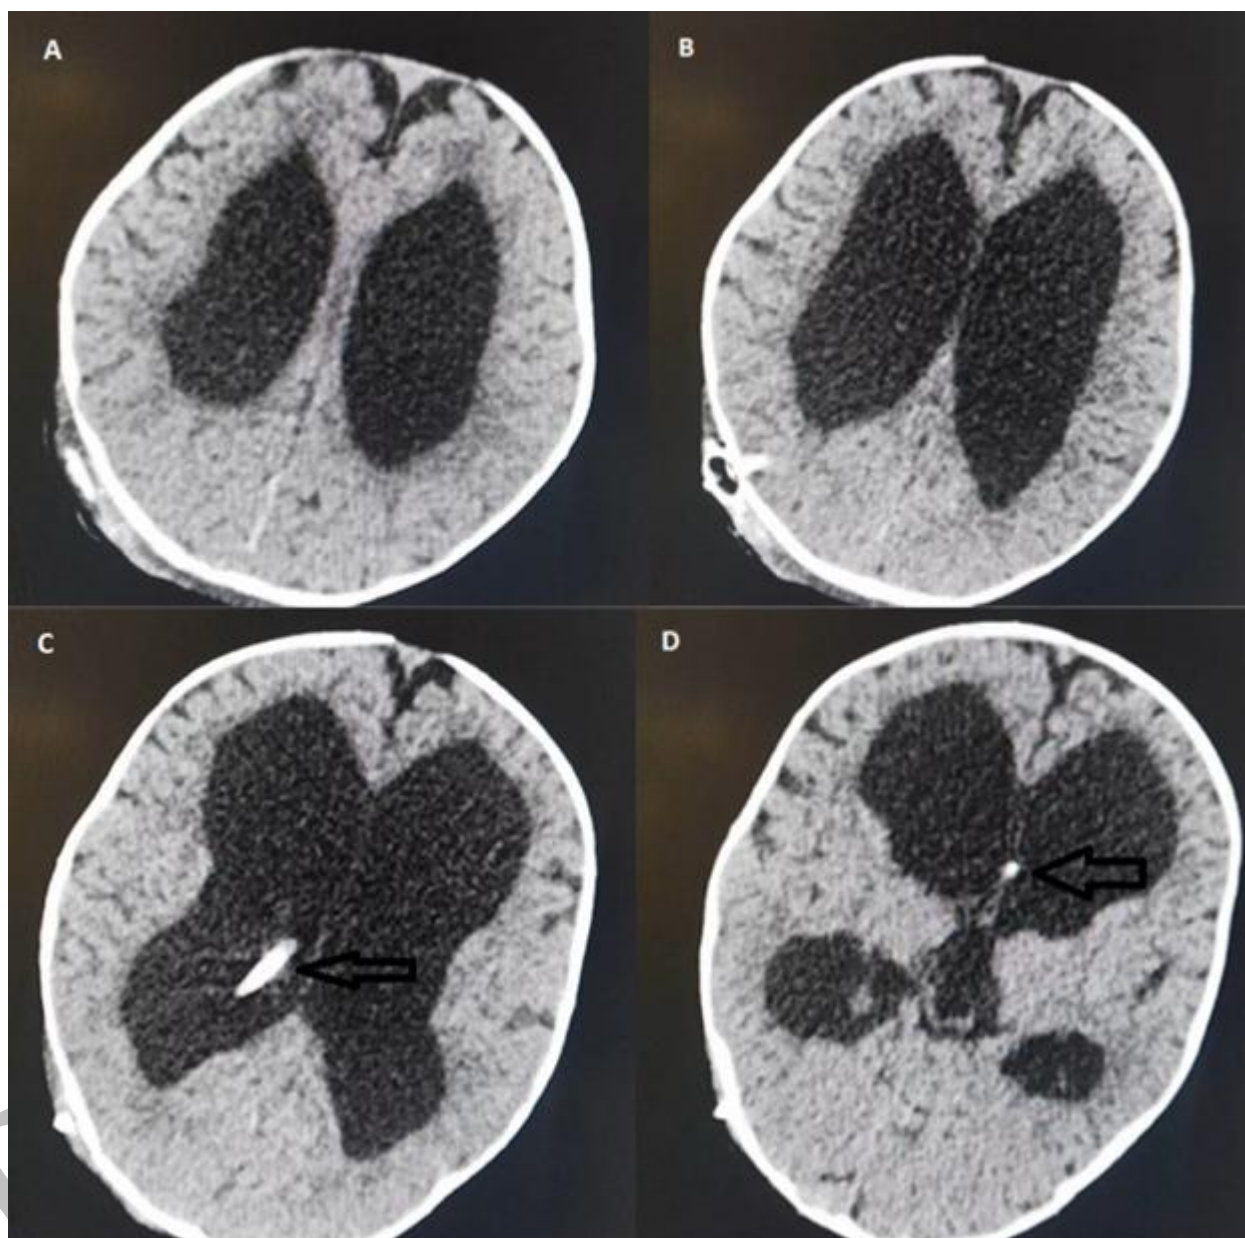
Postoperative native computed tomography of endocranium scan (after ventriculoperitoneal shunt placement): A, B – still dilated lateral ventricles; C – shunt in situ (“arrow”); D – tip of the shunt in left lateral ventricle (“arrow”)
